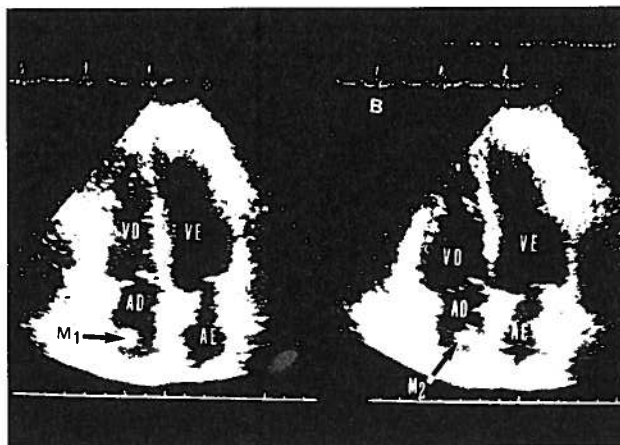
B-mode echocardiogram:(4 chambers): two right intra-atrial masses (M1 and M2)
